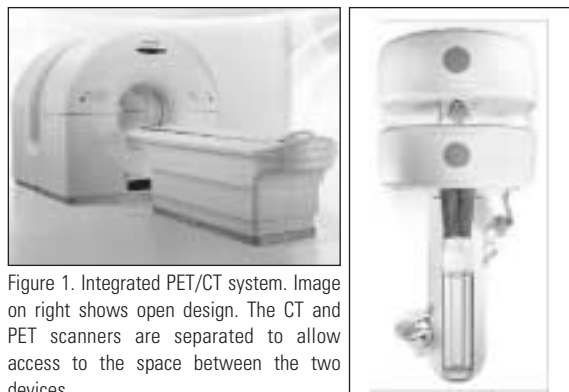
Integrated PET/CT system. Image on right shows open design. The CT and PET scanners are separated to allow access to the space between the two devices.
